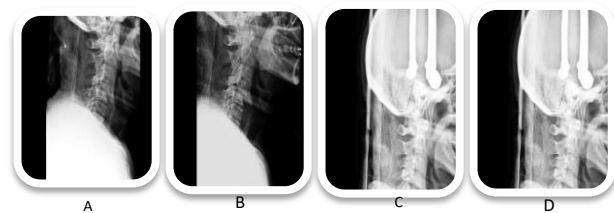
Serial X-ray radiography under cranial traction (A, B, C); C-arm imaging just before surgery (D); cervical spine alignment was corrected under cranial traction
